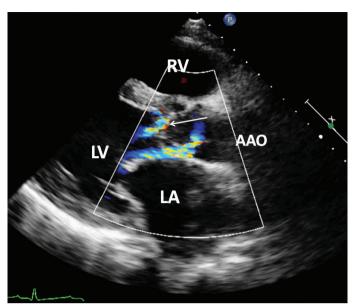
Color Doppler echocardiography showing perforation (arrow) of the aneurysm as a cause of aortic regurgitation. AAO - ascending aorta
